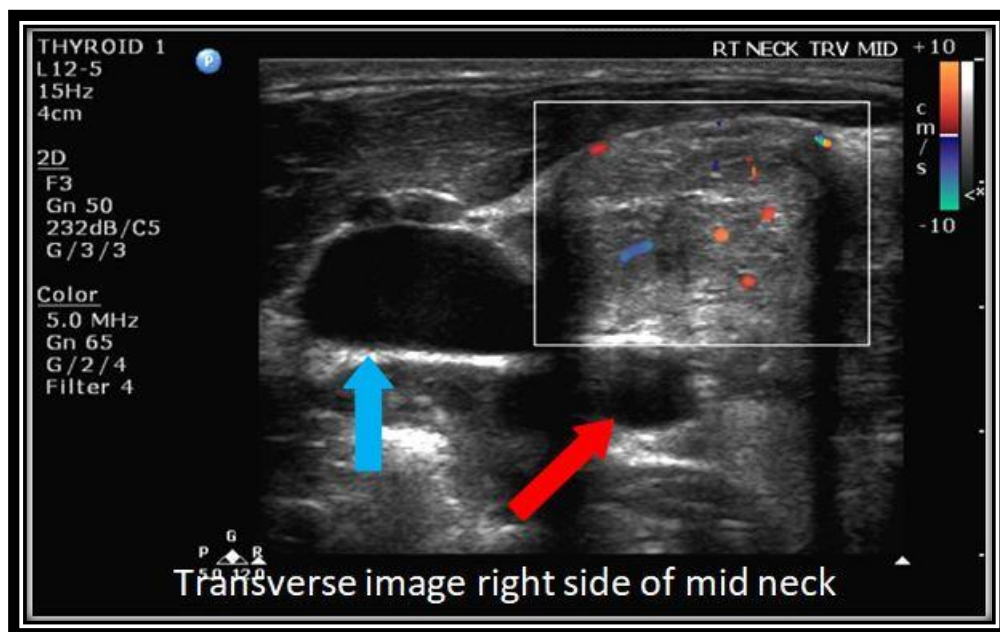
C: Was taken at about the same level as image B and shows increased flow on color Doppler as evident by the red and blue spots in the color box; Again the right internal jugular vein and right common carotid artery are marked by the blue and red arrows respectively
